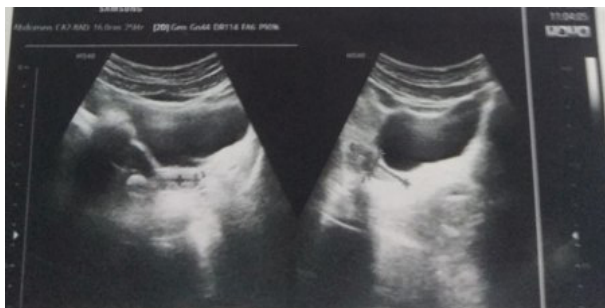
Ultrasonography showing hypoplastic uterus.
